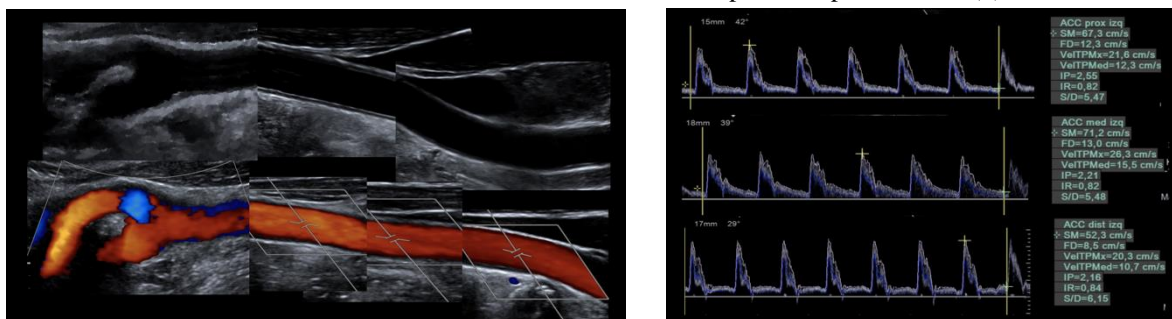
47-year-old woman with a normal carotid artery. A carotid artery from the proximal third to the bifurcation in B-mode, Carotid artery from the proximal third to the bifurcation in color Doppler mode. Spectra and results after evaluation in spectral Doppler mode of the common carotid artery (CCA). Evaluation of three portions of the CCA is observed, with spectra tending to triphasic morphology, rhythmic, with maximum picosystolic velocities (PS) of 71.2 cm / s, normal findings.
